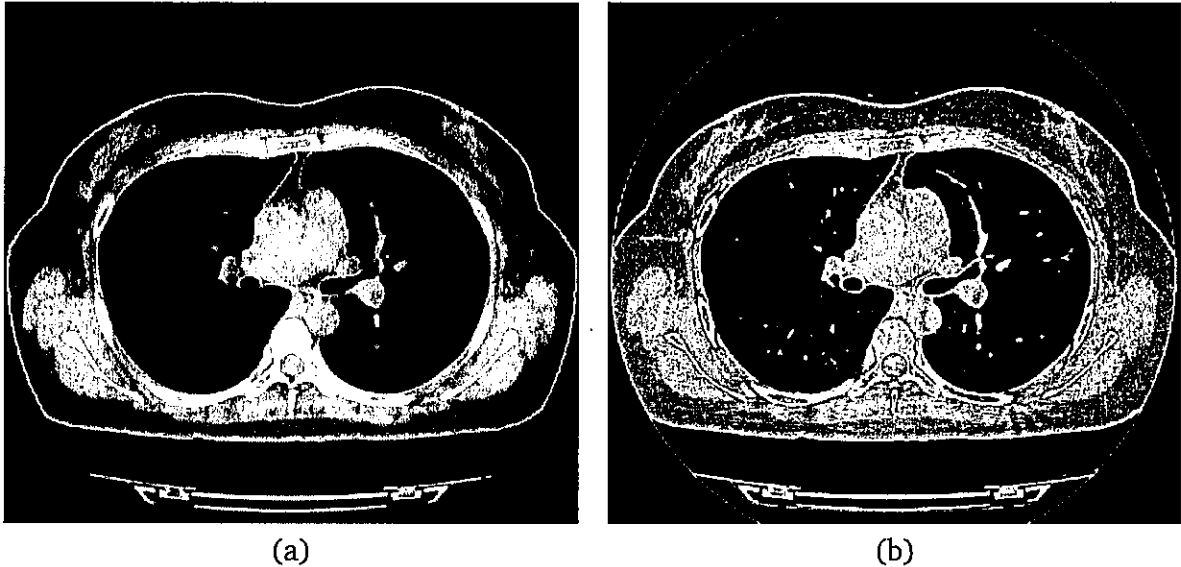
Preprocessing procedure. (a) axial slice of the CT volume. (b) output of sharpening filter.
